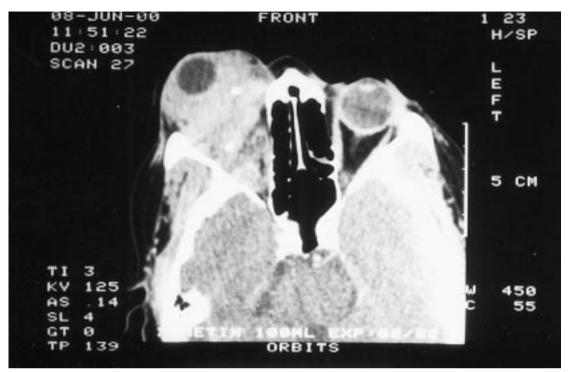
CT-scan : calcifications are present within the tumour.
